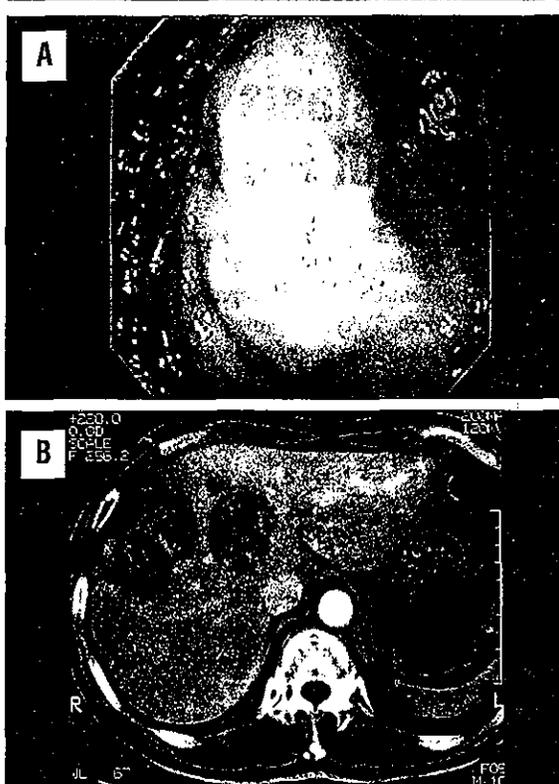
(A) Endoscopic examination revealed submucosal tumor at the greater curvature in the upper body of stomach. The surface of the tumor was covered by normal gastric mucosa without ulceration. (B) Contrast-enhanced CT scan showing gastric tumor growing outward with two low-density areas in the right lobe of the liver.
